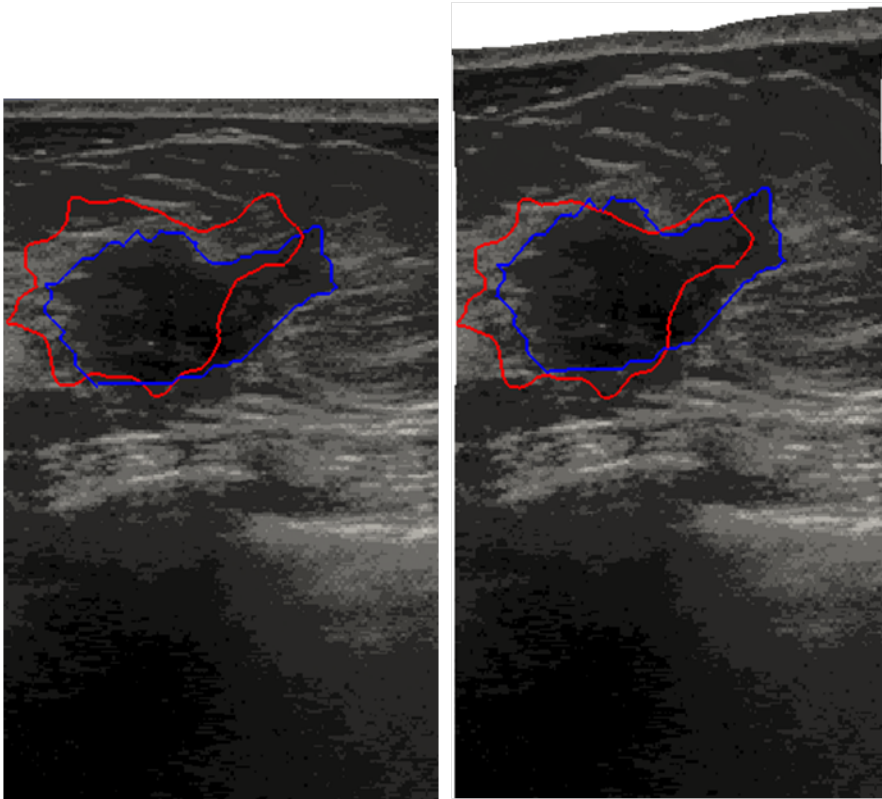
Left: Uncorrected ultrasound slice with uncorrected ultrasound tumor contour (blue) and MR contour (red). Right: corrected ultrasound slice with ultrasound tumor contour (blue) and MR contour (red).
